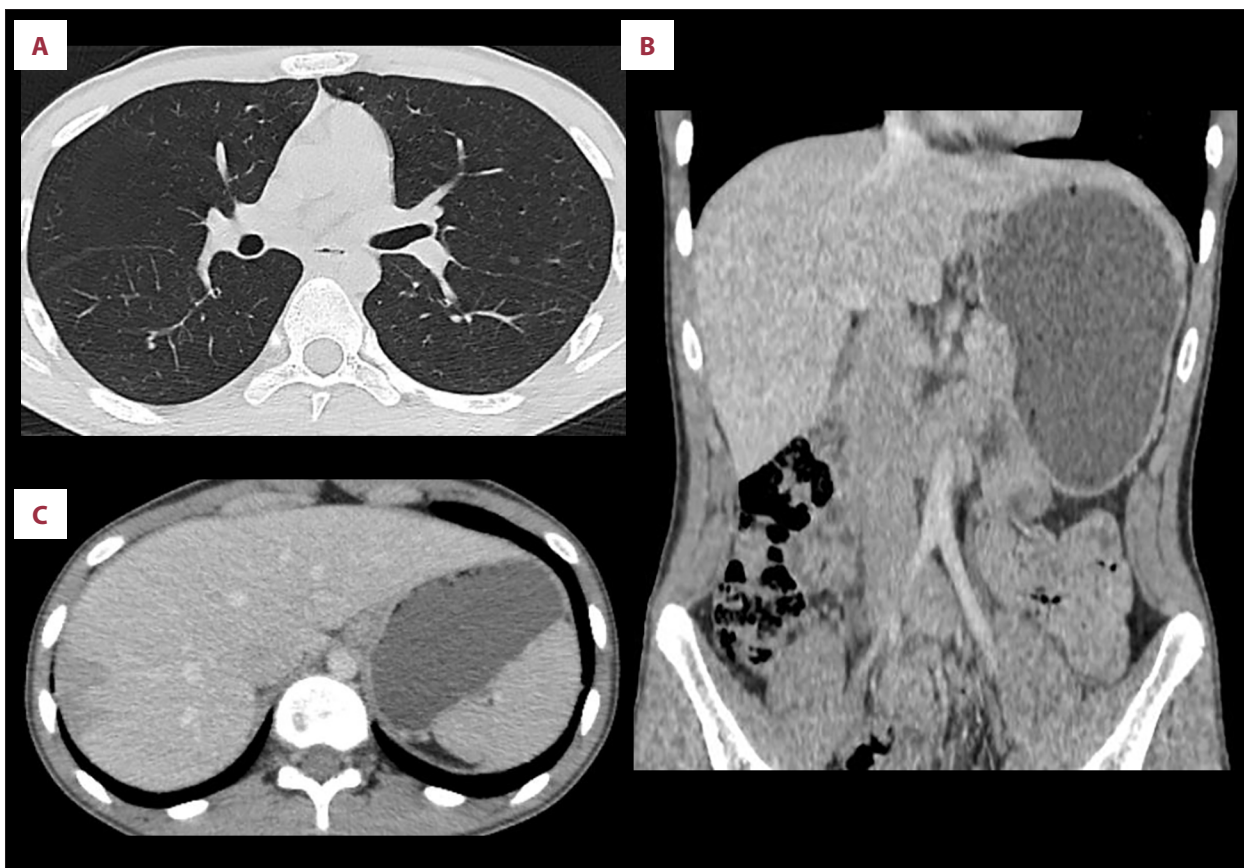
Follow-up contrast-enhanced computed tomography (CT) approximately 2 months after surgery.(A-C) Axial and coronal CT images demonstrating postoperative changes following Hartmann's procedure without evidence of local recurrence, lymph node enlargement, or distant metastatic disease. Previously identified pulmonary nodules remained unchanged.
